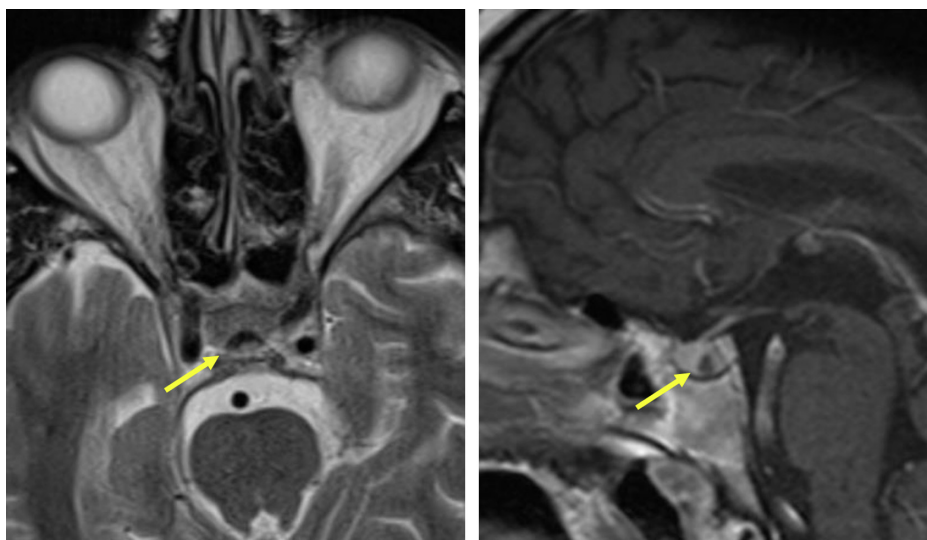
In the pituitary MRI, a 4 mm lesion suspicious of adenoma or cyst is seen at the tip of the arrow.
